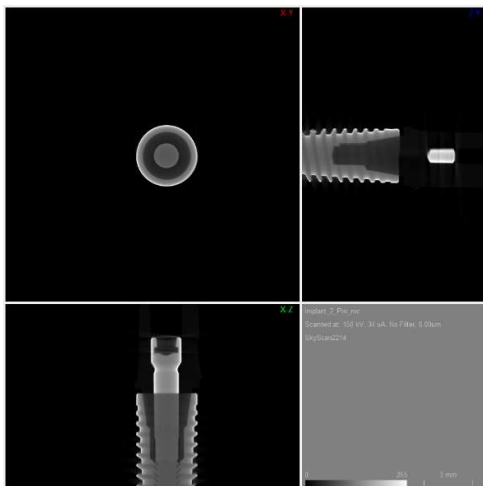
Pre Load Nano CT of Ti Implants and PEEK Abutments shows no Leakage
